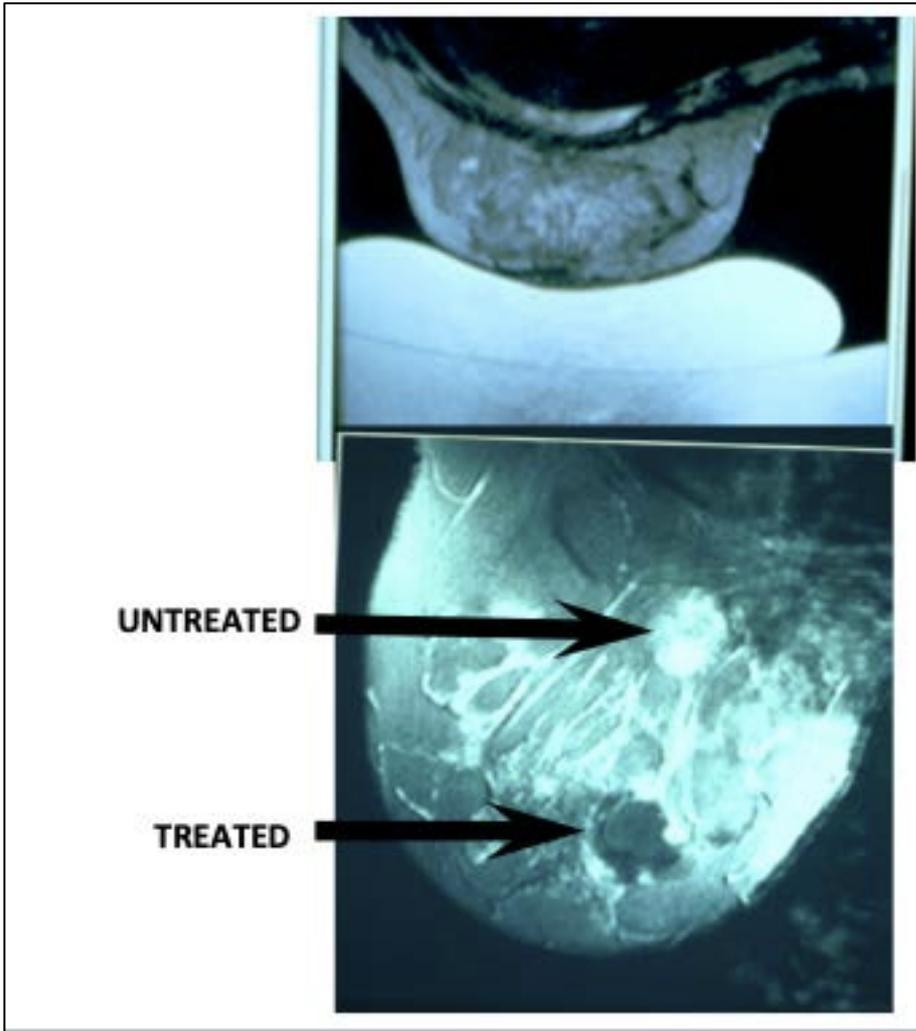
initial application of MR guided Focused ultrasound to ablate benign breast tumors.
